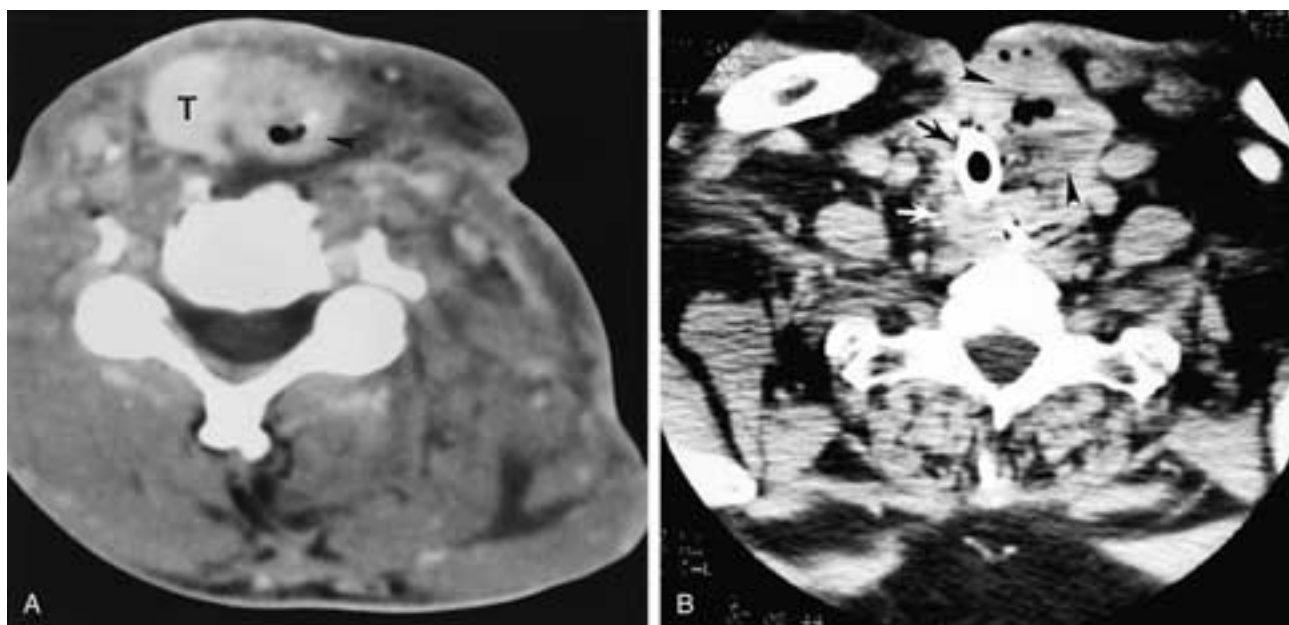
Axial CT. A, Postoperative laryngectomy and bilateral radical neck dissection. The esophagus has migrated anteriorly (*arrowhead*) to lie in the usual position of the trachea next to the thyroid gland (*T*). The sternocleidomastoid and jugular veins have been removed. B, Lower scan. The tracheostomy tube is seen documenting the position of the airway (*black arrow*). The esophagus is seen immediately posteriorly (*white arrow*). Note the large stomal recurrence (*arrowheads*).
